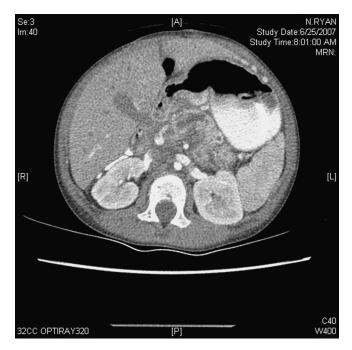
Abdominal computerized tomography (CT) indicating an injury in the posterior mid-body of the pancreas with a fistula from the retroperitoneum into the mediastinum and left hemithorax.
